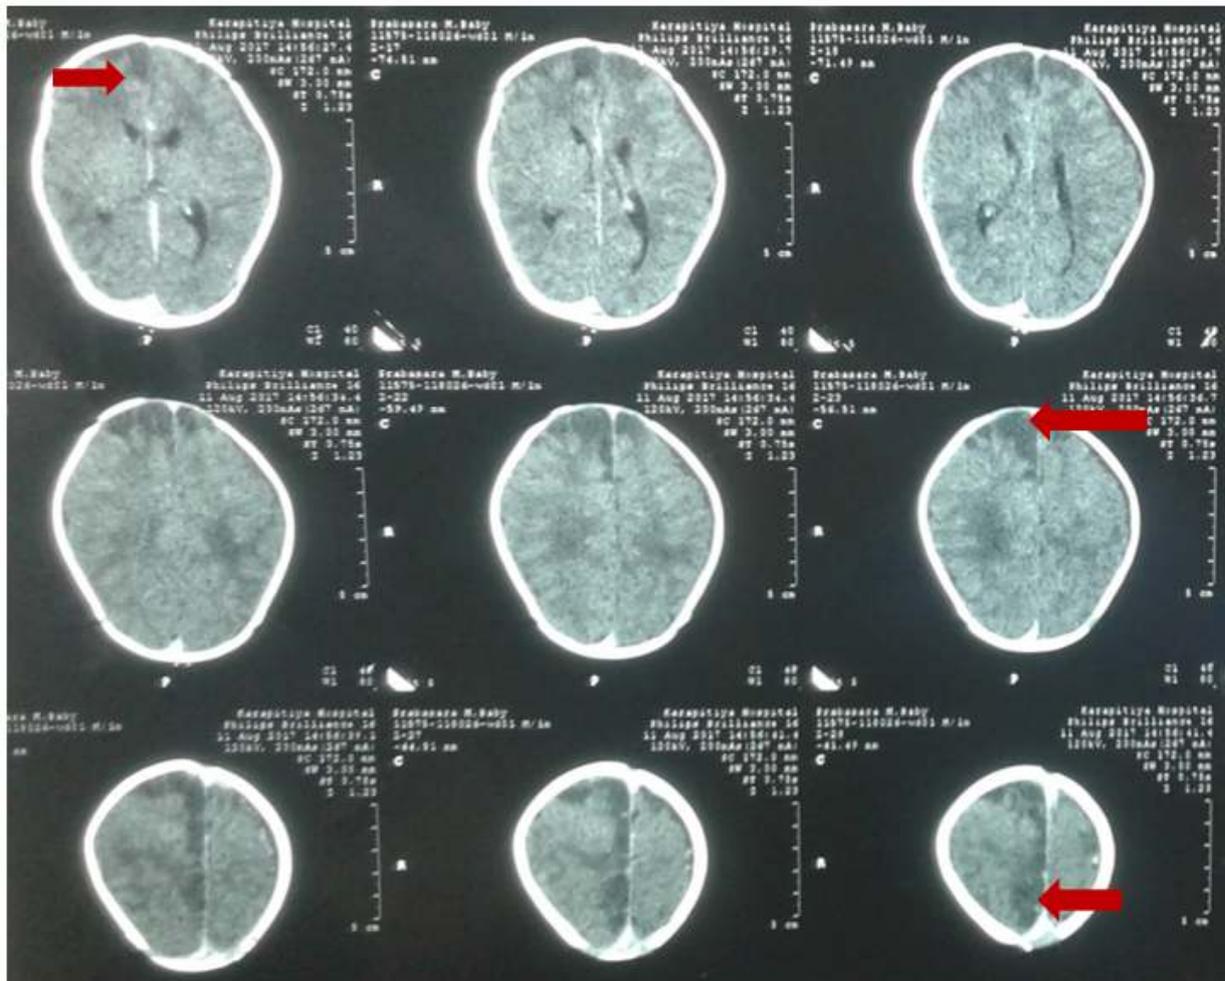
Contrast enhanced computed tomography of brain suggestive of diffuse cerebritis
